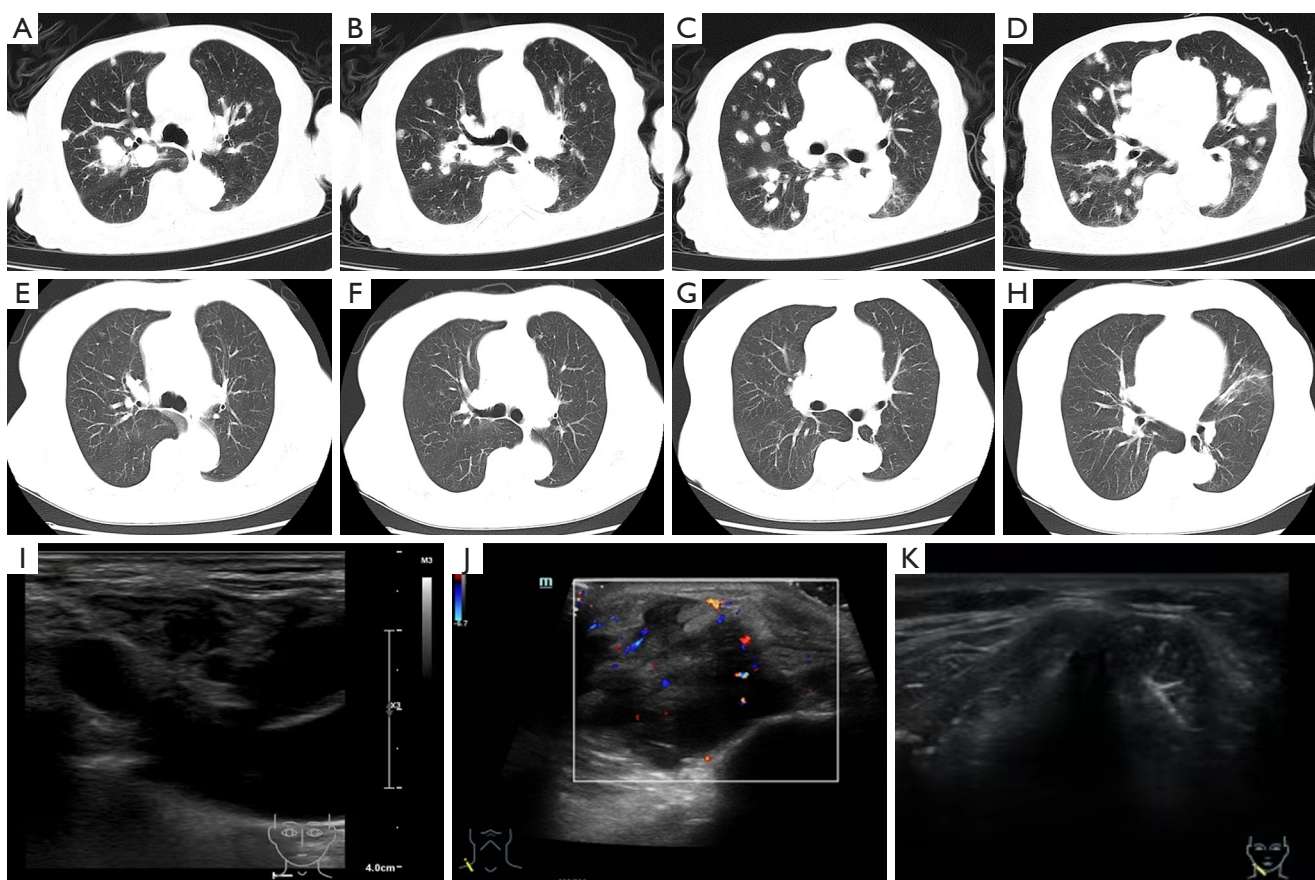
CT of the lung and the color and Doppler imaging of the left clavicle for the patient. (A-D) CT images at the diagnosis stage in July 2021. (E-H) CT images after the combination of zanubrutinib and R-miniCHOP therapy in May 2022. (I-K) Color Doppler imaging at the diagnosis stage in July 2021 (I), disease progression in March 2022 (J) and complete response in May 2022 (K). CT, computed tomography; R-miniCHOP, rituximab plus attenuated standard chemotherapy.
